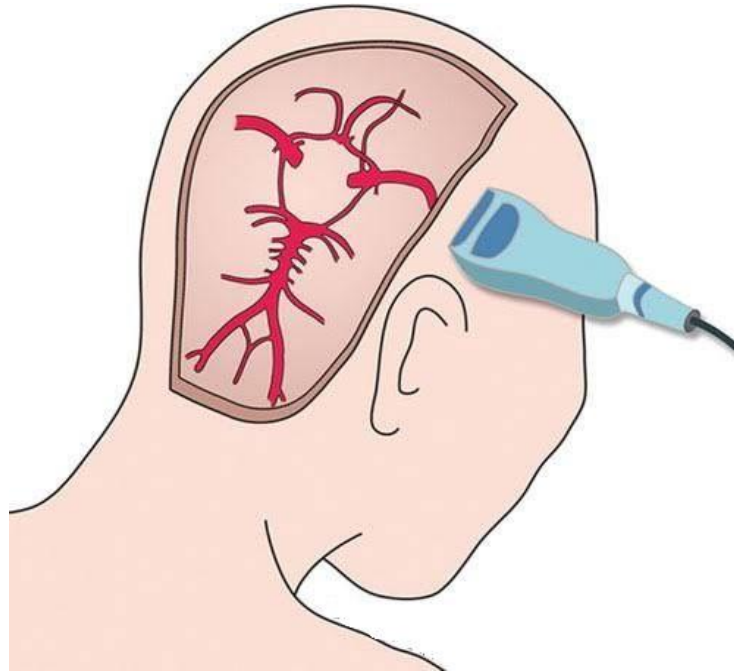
TRANSCRANIAL DOPPLER
